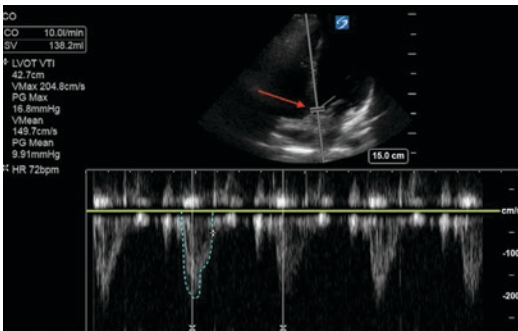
Image demonstrating the placement of the Doppler gate (arrow) parallel to the direction of flow in this apical view. Blood is flowing either from the bottom of the image towards the top (across the mitral and tricuspid valves) or from the top to the bottom (across the aortic valve)
